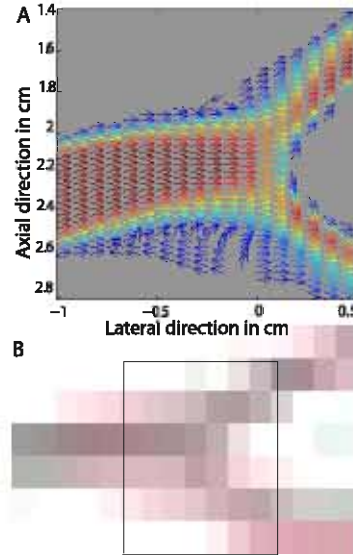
Panel A shows the complex swirling flow field as given in-plane when the ultrasonic scanning sequence is taken into account. In panel B the actual flow field generated from CFD is shown at a time halfway through the scan sequence. Due to scanning time lags this instantaneous velocity field cannot be captured.
